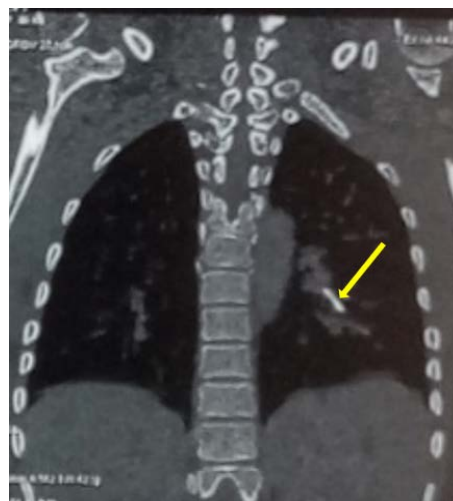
Frontal section of the chest CT scan showing an implant in the left pulmonary artery.
